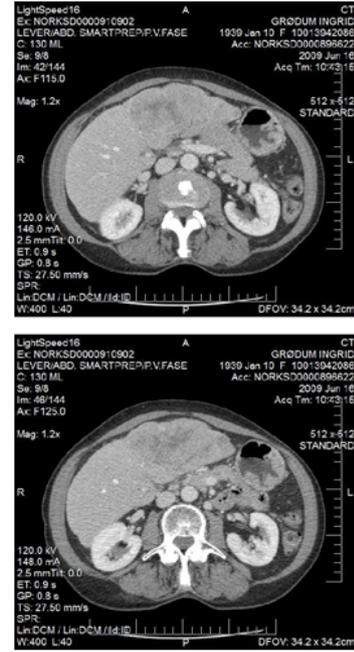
(a): Massive liver metastases on CT scan abdominal CT scan at the beginning of treatment.
